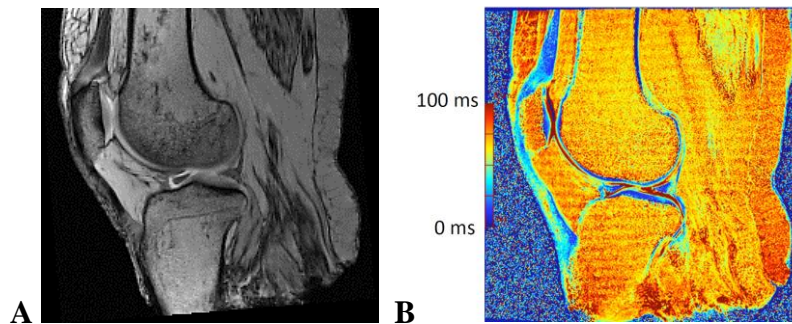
A. Morphologic MRI (qDESS, 1st echo) & B. qMRI (T_2 relaxation) sample slices; note soft tissues presence
